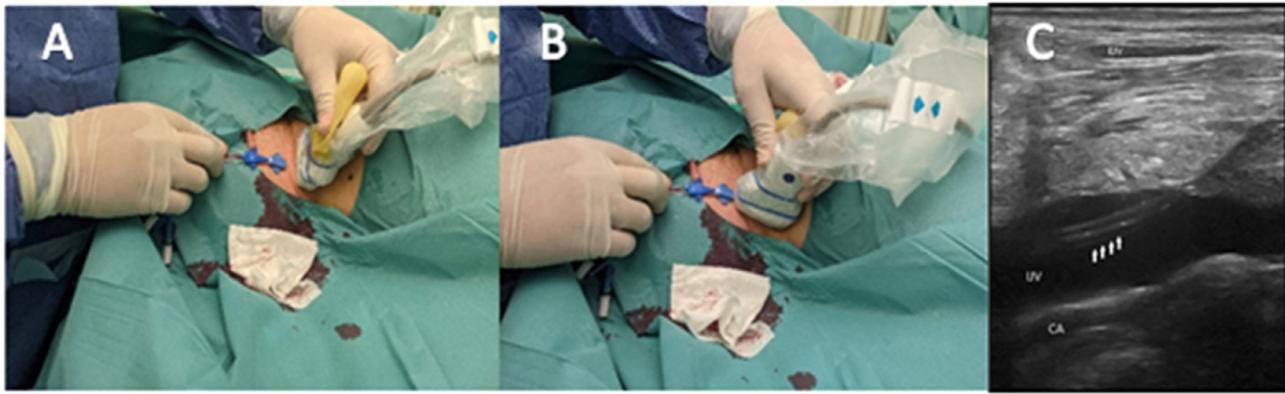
A, Probe orientation for the out-of-plane approach to confirm the correct position of the CVC; B, Probe orientation for the in-plane approach to confirm the correct position of the CVC; C, Direct ultrasound image of the CVC inserted inside the IJV in the in-plane approach. CVC, Central Venous Catheter; EJV, External Jugular Vein; IJV, Internal Jugular Vein; CA, Carotid Artery; ↑↑↑↑, Central Venous Catheter.
